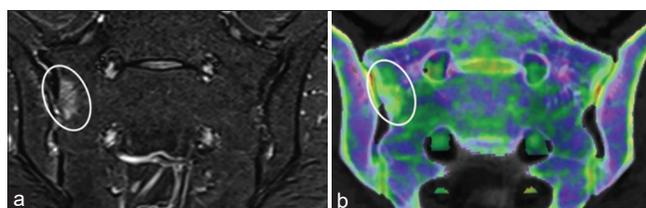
Magnetic resonance imaging and dual energy computed tomography of a 29-year-old female with sacroiliitis. (a) Magnetic resonance short-T1 inversion recovery image demonstrates subchondral high signal in the right sacroiliac joint (circle), representing bone marrow edema. (b) Bone marrow edema (circle) is displayed as bright green areas with yellow and red spots on the dual-energy computed tomography image
